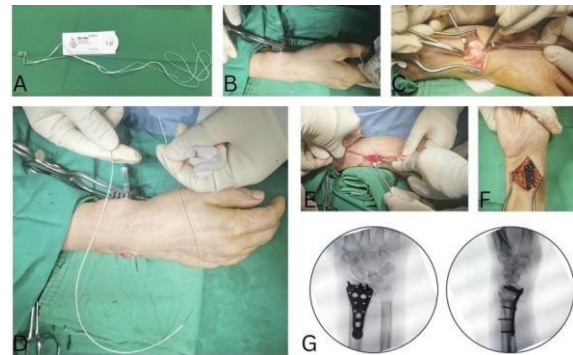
(A) Synthetic biotape graft. (B) Creation of a bone canal for the biotape fixation pathway. (C) Surgical approach to expose the ulnar head. (D) The biotape is inserted into the canal with the assistance of an Abbocath. (E) The biotape after fixation in the prepared canal. (F) Clinical photograph following plate fixation of the distal radius. (G) Postoperative radiographic evaluation demonstrating plate fixation of the distal radius and reconstruction of the distal radioulnar joint (DRUJ).
